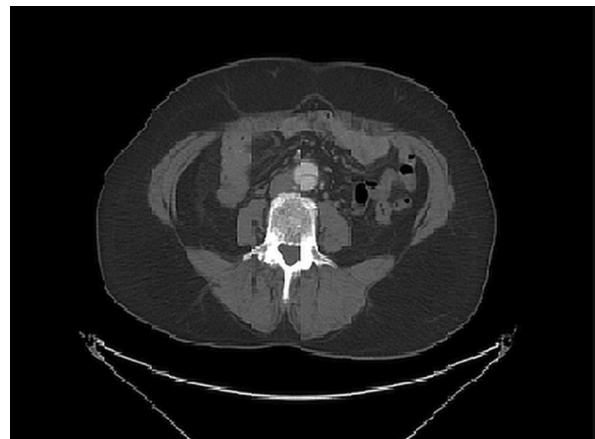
An axial view of computed tomography (CT) of the abdomen during arterial phase showing spontaneous infrarenal abdominal aorta dissection without change for 4 years.
